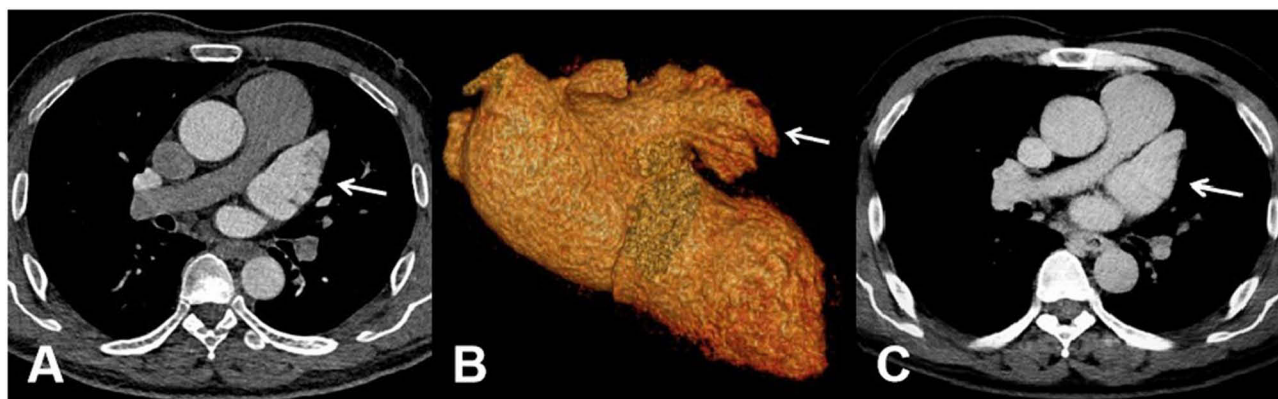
Female, 67 years old, Flash large-spiral arterial late scan. The distal end of LAA in the arterial late phase of CTA axial and VR images were fully filled and clearly displayed (arrow), (A and B), and the LAA in the delayed phase was completely and evenly filled (arrow), (C).
